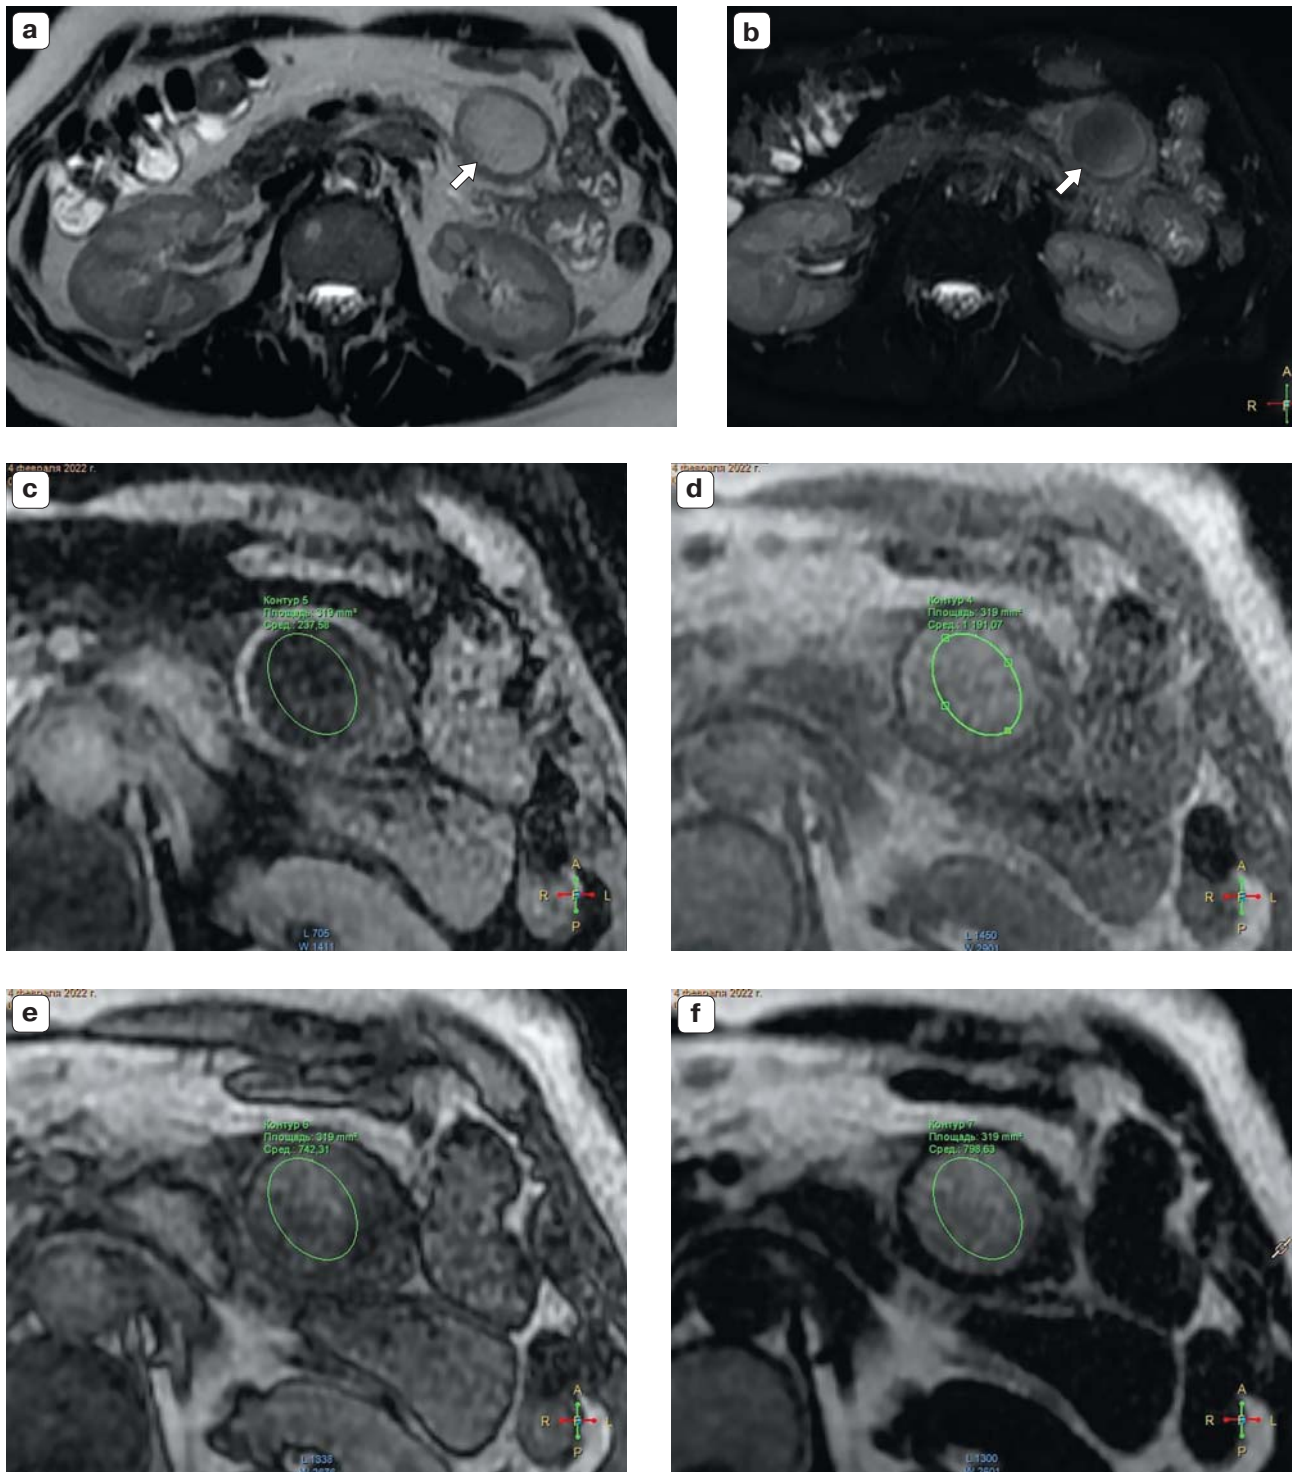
Magnetic resonance imaging, axial section. a – T2-WI – thick-walled pathological formation in the root of the mesentery of the small intestine with a moderately high intensity of the MR signal (arrow). b – T2-WI FS shows suppression of the signal by part of the lesion (arrow); c–f – Lava-Flex mode: c– water; d – In-phase; e – Out-phase; f – Fat. Ellipse – ROI area of interest for determining signal intensity values.
